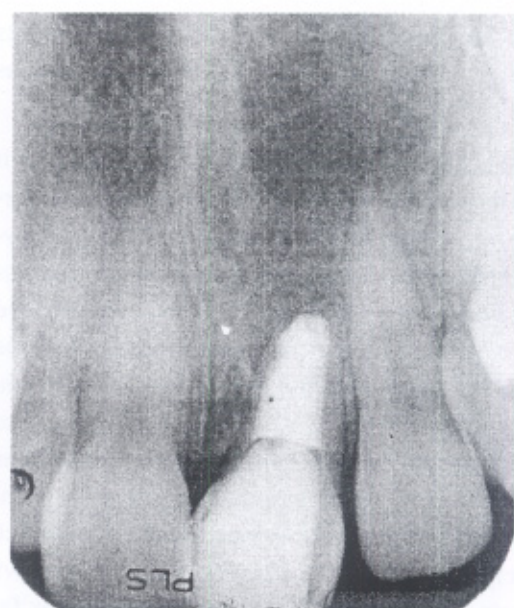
Six-month recall radiograph shows considerable osseous repair around the apex of the root.
